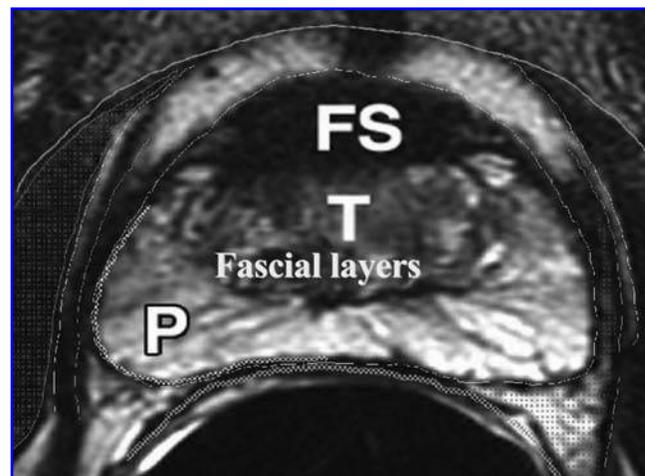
MRI showing the distribution of the fascial layers around the prostate. FS=fibromuscular stroma; P=peripheral zone; T=transition zone.
